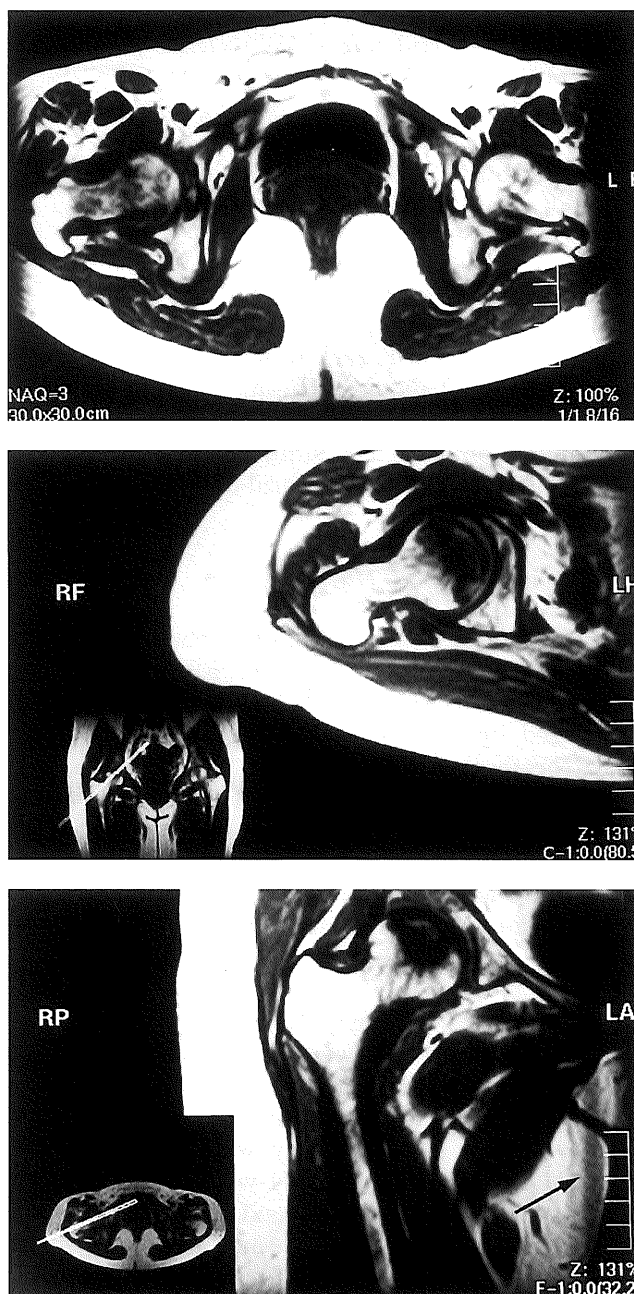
T1-weighted MR image (500/15) of a 52-year-old woman with avascular necrosis of both femoral heads. (a) Axial image of both hip joints. No slice shows the femoral head, the femoral neck, and the intertrochanteric region completely. (b) Oblique axial image of the right hip joint. This slice shows the femoral head, the femoral neck, and the intertrochanteric region completely. There are two other excellent images in addition to this one. (c) Bilateral simultaneous oblique coronal image of the right hip joint. Image quality is degraded in medial regions where the two oblique planes intersect (arrow).
